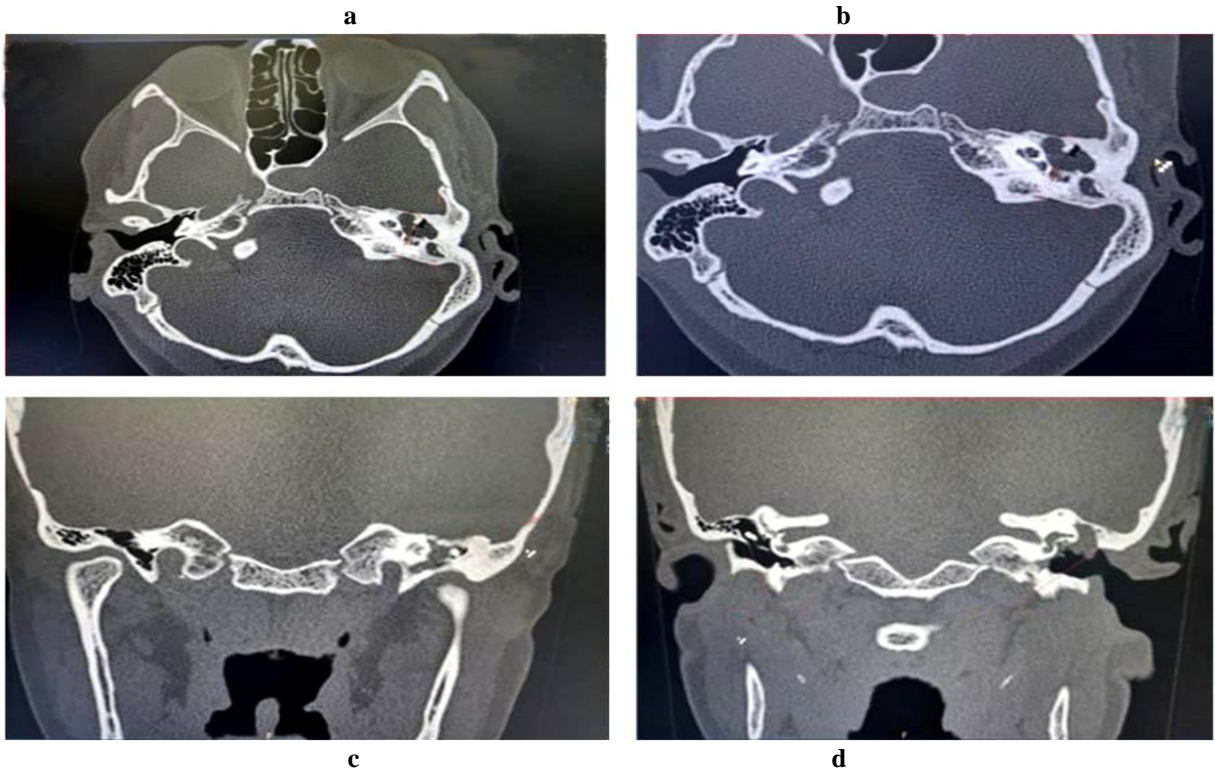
(a and b) Abnormal soft tissue in the left middle ear cavity with displacement & erosions of the middle ear ossicles. Articulation between the incus & the malleus is maintained. (c) Coronal HRCT of the same patient as above demonstrates abnormal anterior displacement of the ossicles. (d) Coronal HRCT image in the same patient at the level of scutum demonstrates scutum erosions.
